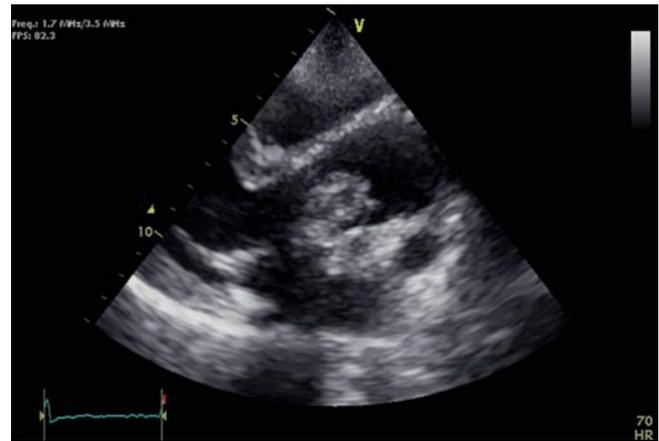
Transthoracic echocardiography showing a large and highly mobile vegetation on the leaflet of a bioprosthesis in the aortic position
